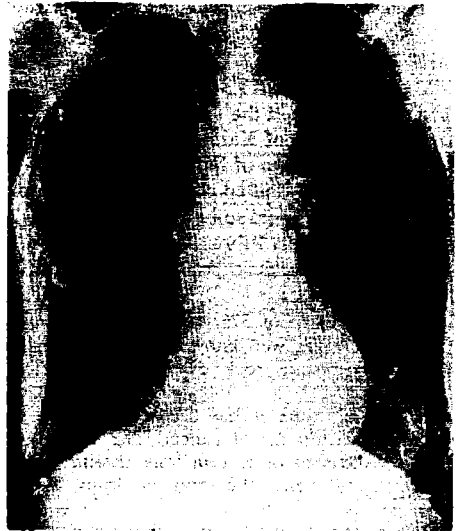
Radiograph of an old woman from Karain showing multiple bilateral calcified pleural plaques.
